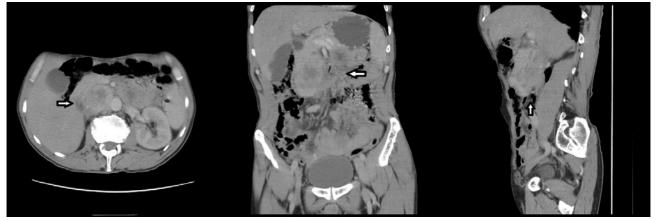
Sample slices of a CT image with arrows indicating tumor mass
